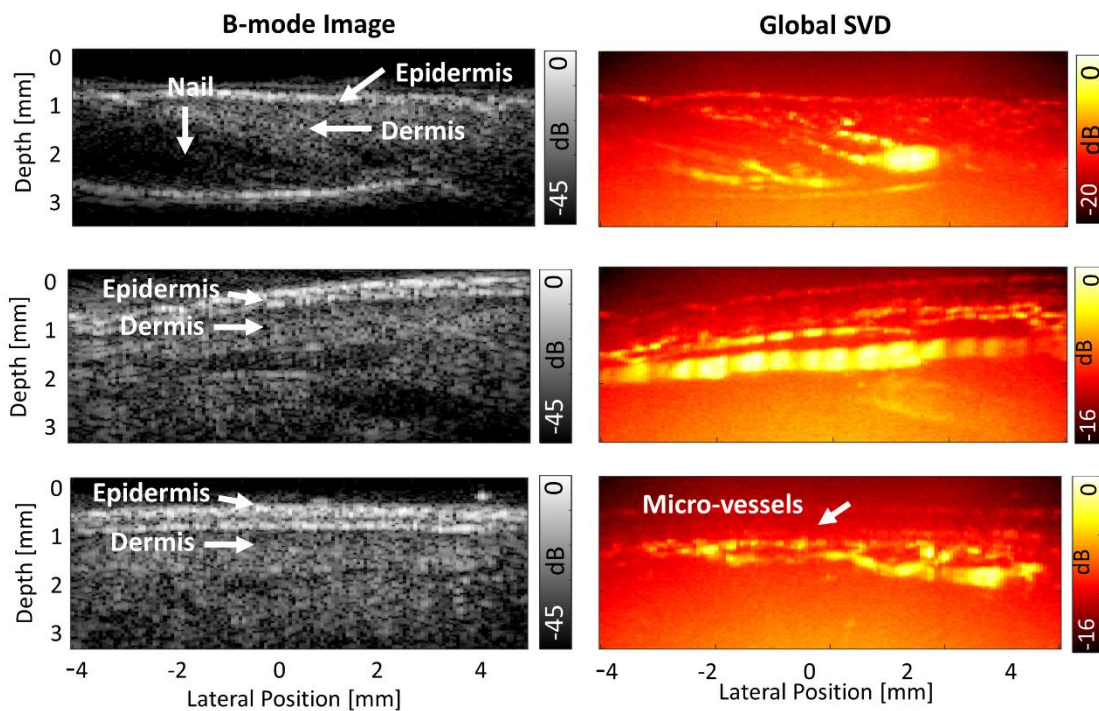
Obtained power Doppler images from three different positions of index finger. (a). Dorsal side nail bed. (b) Distal phalanx in palmar position. (c). Side distal phalanx in palmar position.
